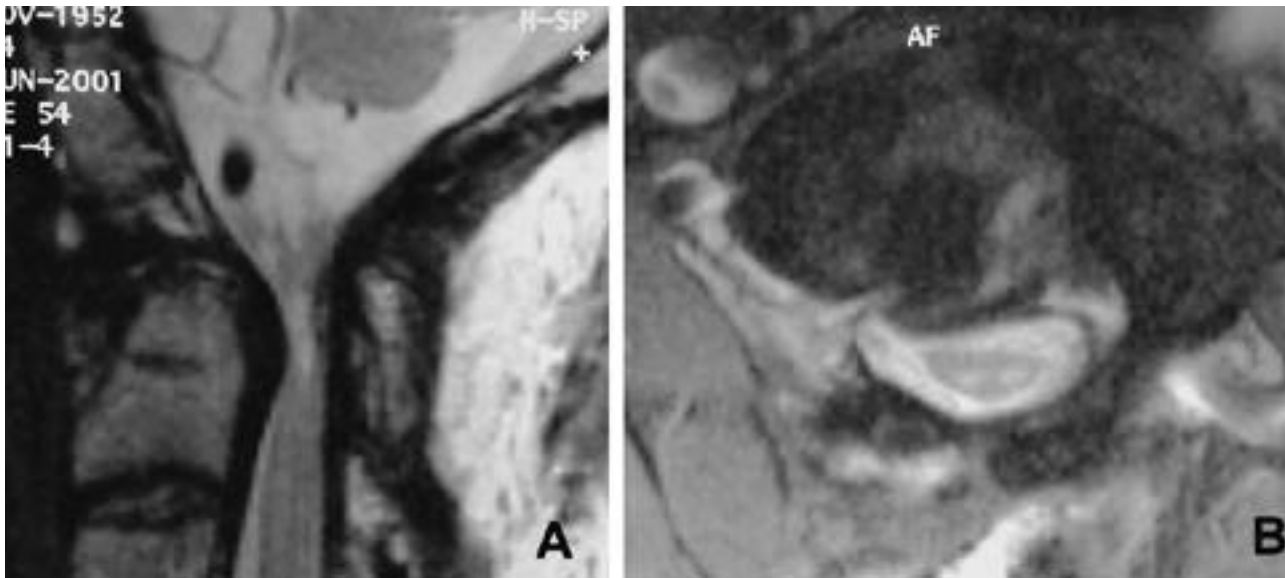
T2-weighted sagittal magnetic resonance (MR) image of cervical spine shows compression of the spinal cord with high signal intensity in the cord (A). T2-weighted axial MR image of cervical spine shows marked compression of the spinal cord with defect in the posterior arch of the atlas (B).
